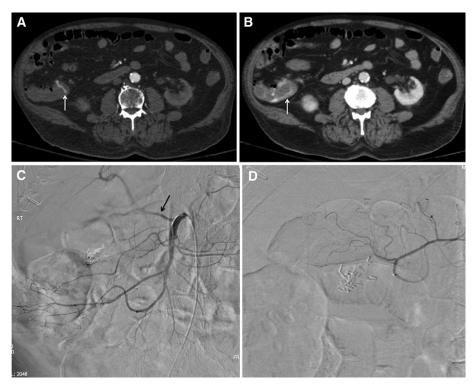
Spontaneous cessation of bleeding after computed tomography (CT) angiography positive for diverticular hemorrhage. The patient improved clinically and has had no evidence of recurrent hemorrhage at 6-month follow up. (A) Axial image from arterial phase CT showing active jet-like arterial enhancement (arrow) in ascending colon at site of diverticulum. (B) Axial image from venous phase of CT shows progressive increasing intraluminal enhancement (arrow). (C) Superior mesenteric artery arteriogram showing lack of active extravsation. (D) Subselective right colic arteriogram confirming lack of extravasation.
